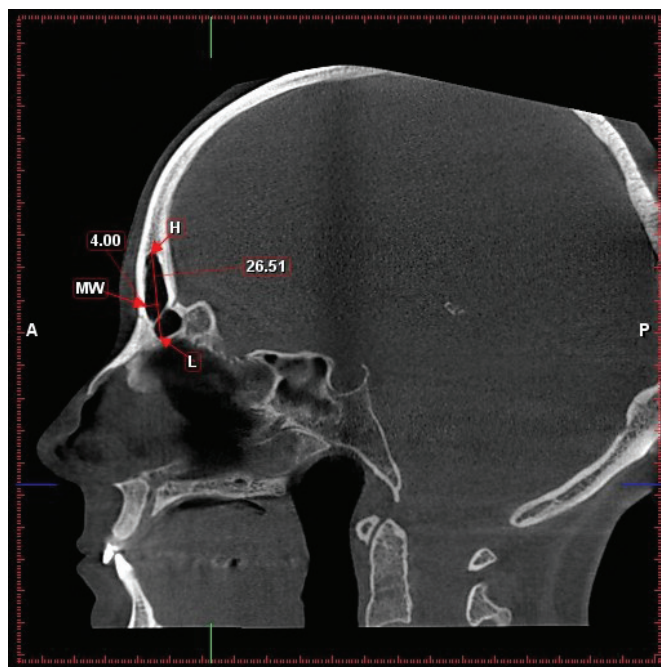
Frontal sinus measurements on mid-sagittal CBCT slice. H-highest point on the frontal sinus; L- lowest point on the frontal sinus; MW- maximum width of the frontal sinus.
